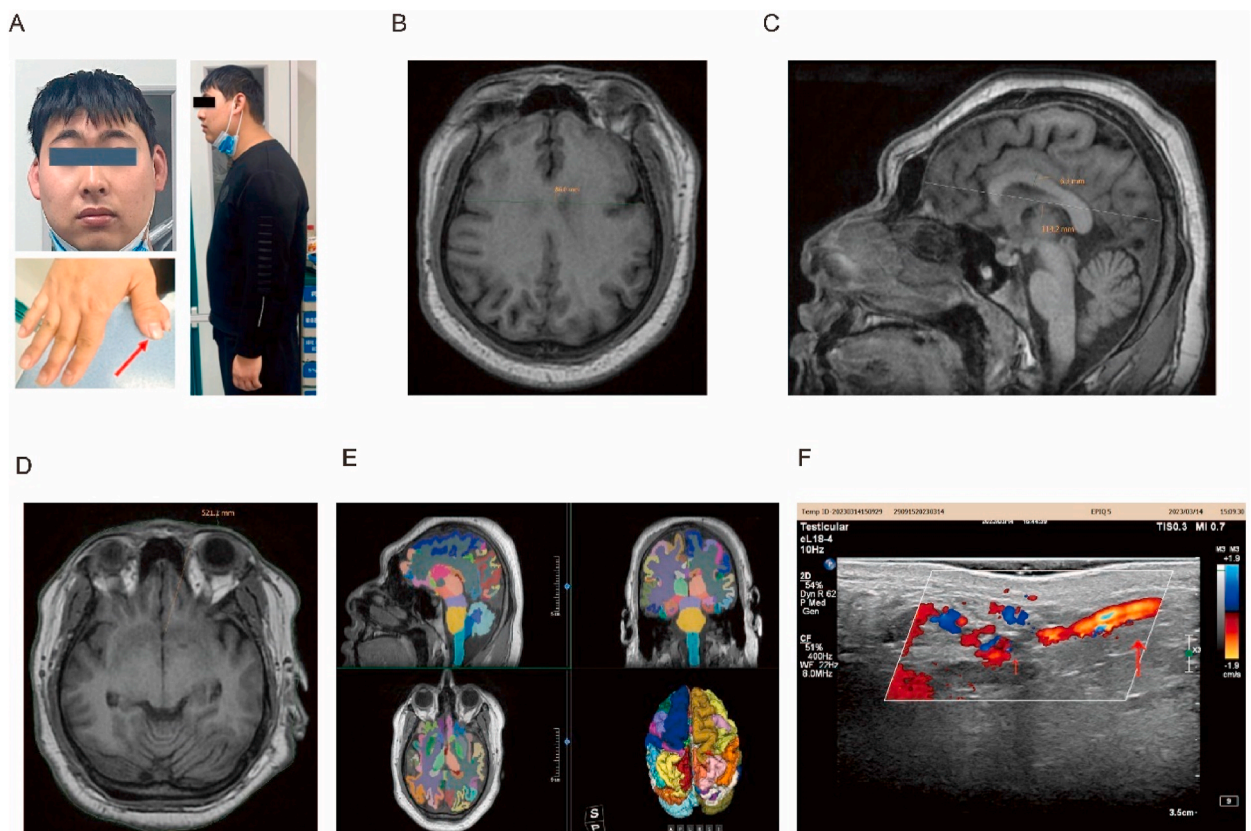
Clinical presentation of the proband with microcephaly. A, physical examination of the proband. The red arrows indicate the probands with deformity of six fingers of the right hand; B, The brain biparietal diameter of the proband in brain MR imaging; C, The brain occipital-frontal diameter of the proband in brain MR imaging; D, The head circumference of the proband in brain MR imaging; E, Calculation of the volume of the key brain regions by brain segmentation software. F, The proband with superficial B-ultrasound of the scrotum.
